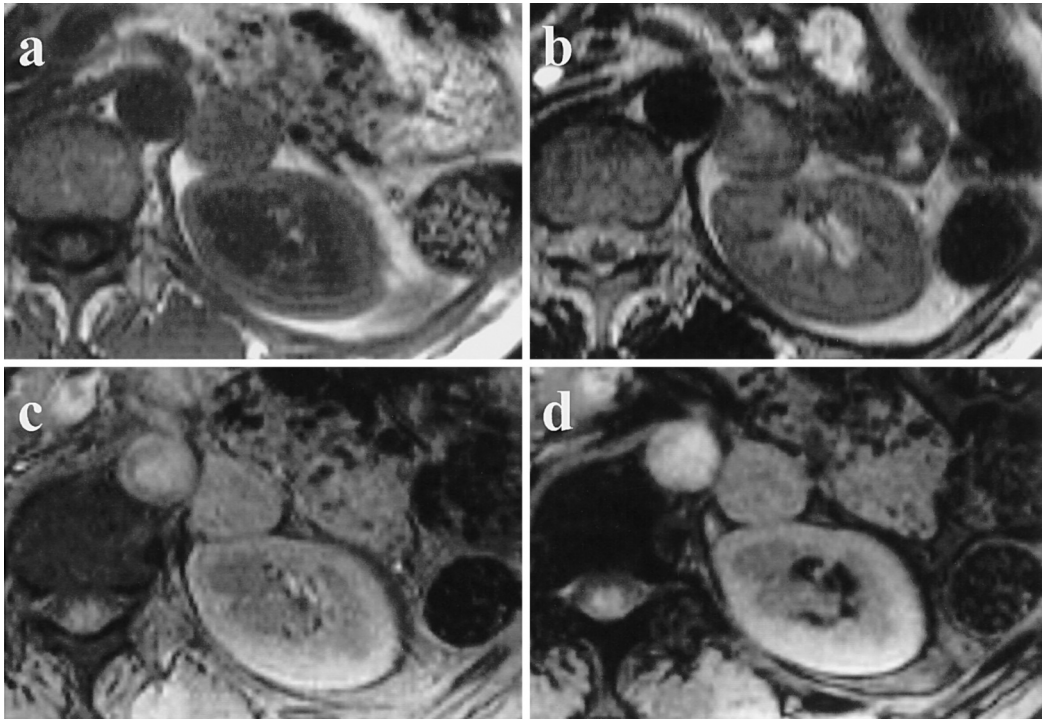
Adenoma. T1-weighted (a) and T2-weighted (b) images demonstrate internal degeneration. In-phase (c) and opposed-phase (d) gradient echo images are also shown. The SI is 4 (gray zone).
